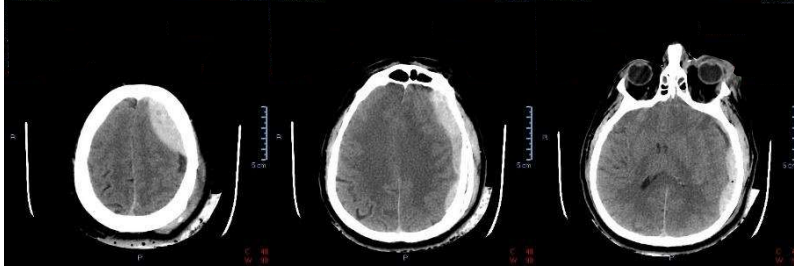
CT images of the patient. The DICOM files were used for the 3D reconstruction and segmentation of the skull. The hematoma is noticeable on the right side of the images (left side of the patient).
